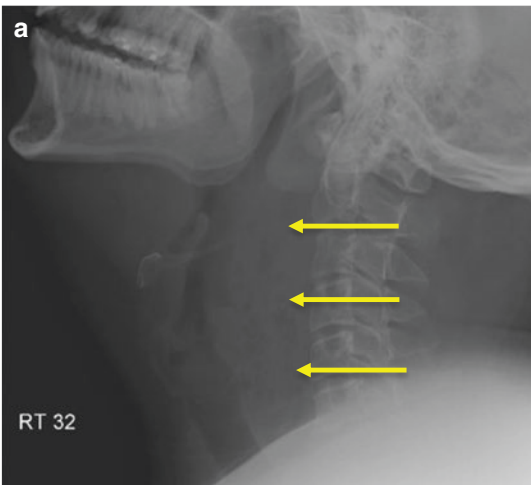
Lateral soft tissue neck radiograph demonstrating widening of the retropharyngeal space (yellow arrow). *Reproduced from Analysing lateral soft tissue neck radiographs, Virk JS et al., 19, 255-260, Emerg Radiol, with kind permission of Springer Science and Business Media*
